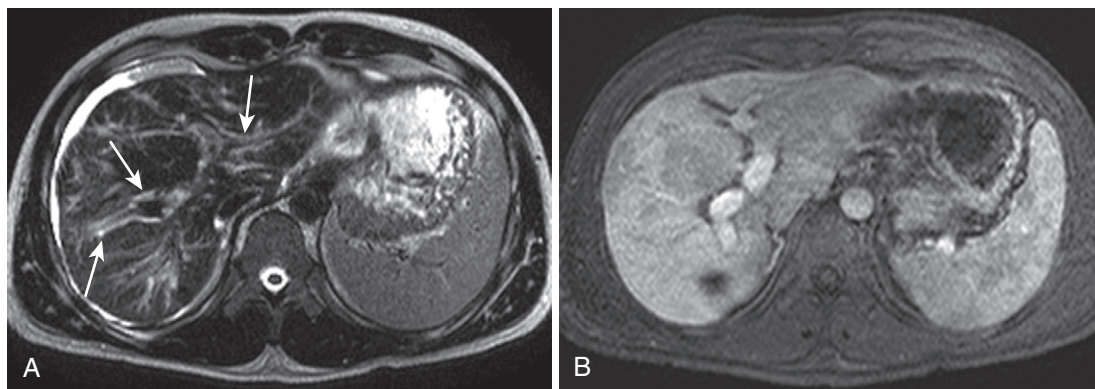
Hepatic inflammation. Periportal edema (arrows in A) and patchy, multifocal parenchymal hyperintensity on the heavily T2-weighted image (A) corresponding to inflammation and edema in a patient with acute fulminant liver failure demonstrate enhancement on the delayed image (B).
